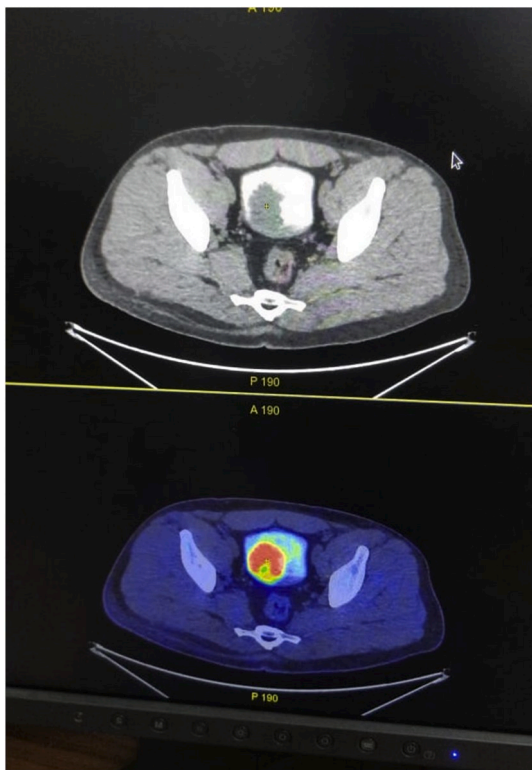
PET CT revealing the FDG avid growth in the bladder.
